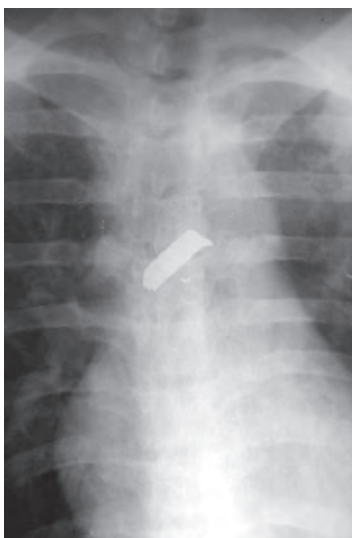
Dorsal spine radiograph showing bullet embedded in the spine
